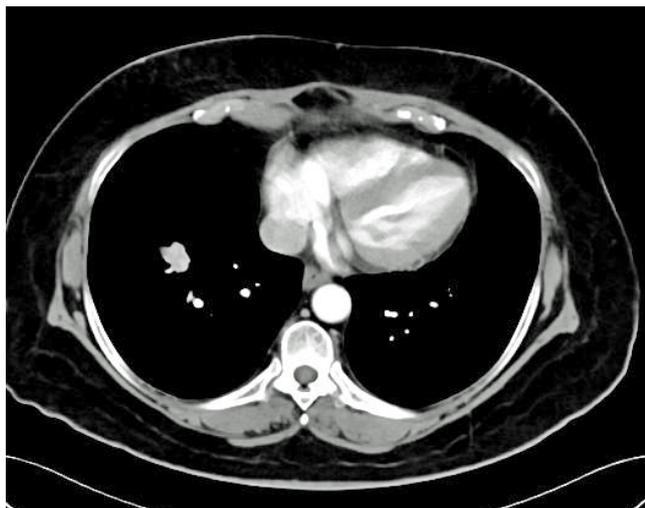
Axial section of the contrast-enhanced CT of the chest showing vascular enhancement in the well circumscribed mass-like lesion
